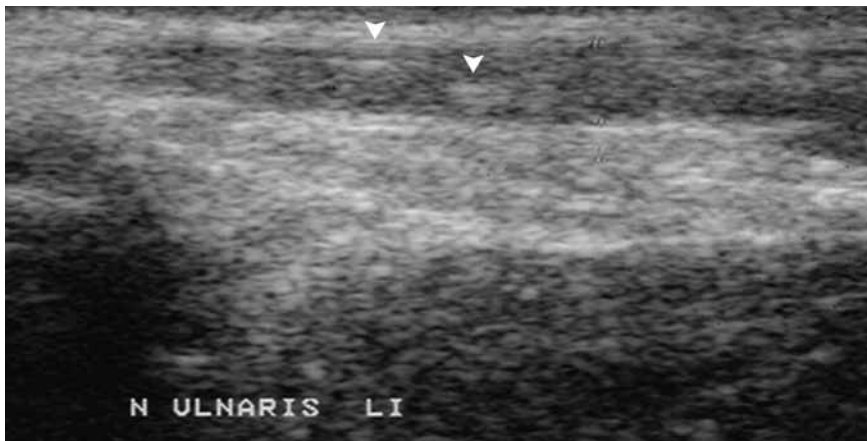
Nerve calcification. Ultrasound of the ulnar nerve shows nerve thickening and internal calcifications (arrowheads).
